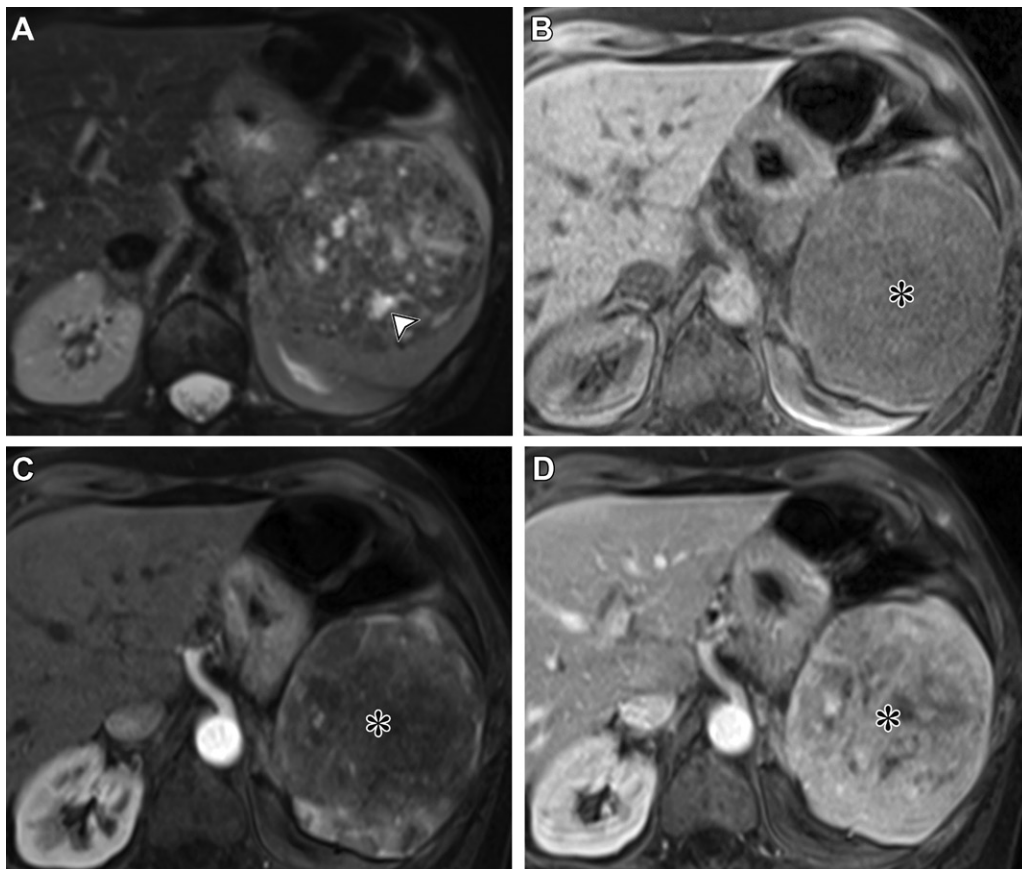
Hemangioma in a 58-year-old woman with progressive sporadic vomiting and sharp left upper quadrant pain. (A) Axial fat-saturated T2-weighted image shows a well-circumscribed solid mass with areas of hyperintense signal (arrowhead). (B) Axial noncontrast T1-weighted image shows that the mass (*) is isointense. (C) Axial arterial phase image shows early peripheral enhancement of the mass (*). (D) Axial portal venous phase image shows progressive homogeneous enhancement of the mass (*).
